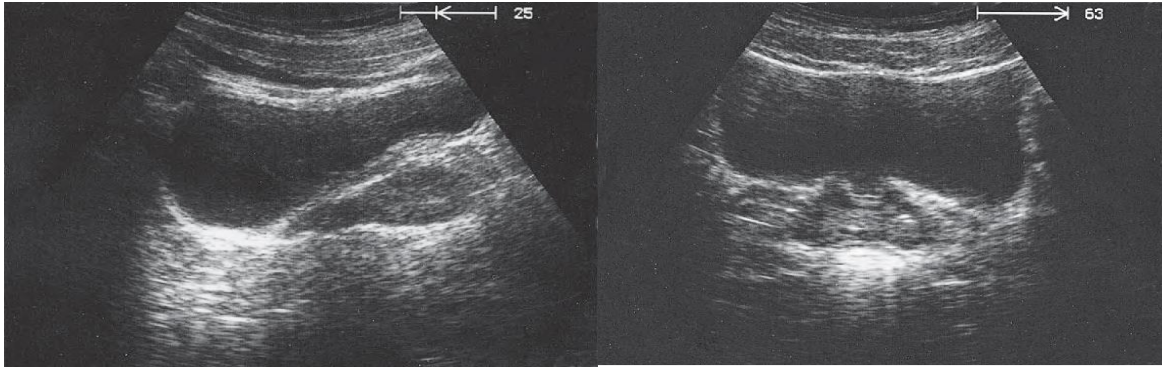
TAUS, longitudinal plane (left), and transverse plane (right), shows; normal prostate sonographic appearance (Block and Telger, 2004).
